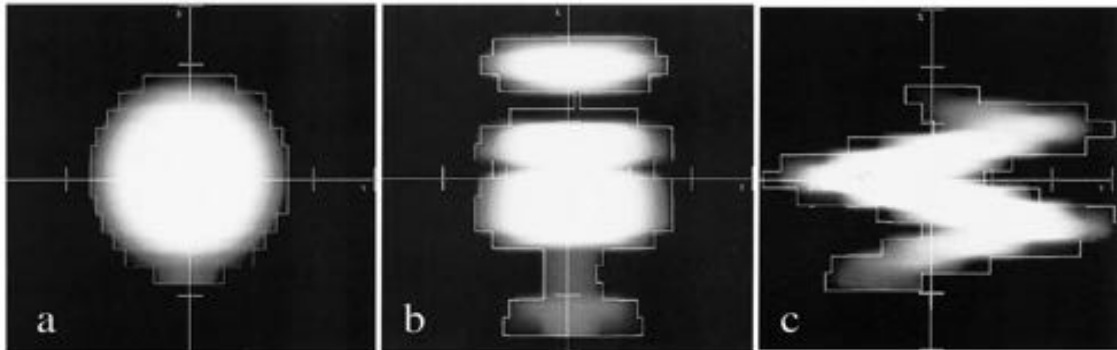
AP DRRs of a 3.2-cm-diameter sphere generated from spiral CT acquisitions while (a) stationary, and moving 25 mm in the (b) longitudinal and (c) transaxial directions. The period was 4 s. The graphical overlay displays the region localized using a threshold of -875 HU. These images show some of the possible distortions that can result in the 3D representations of moving objects acquired using fast, spiral CT.
